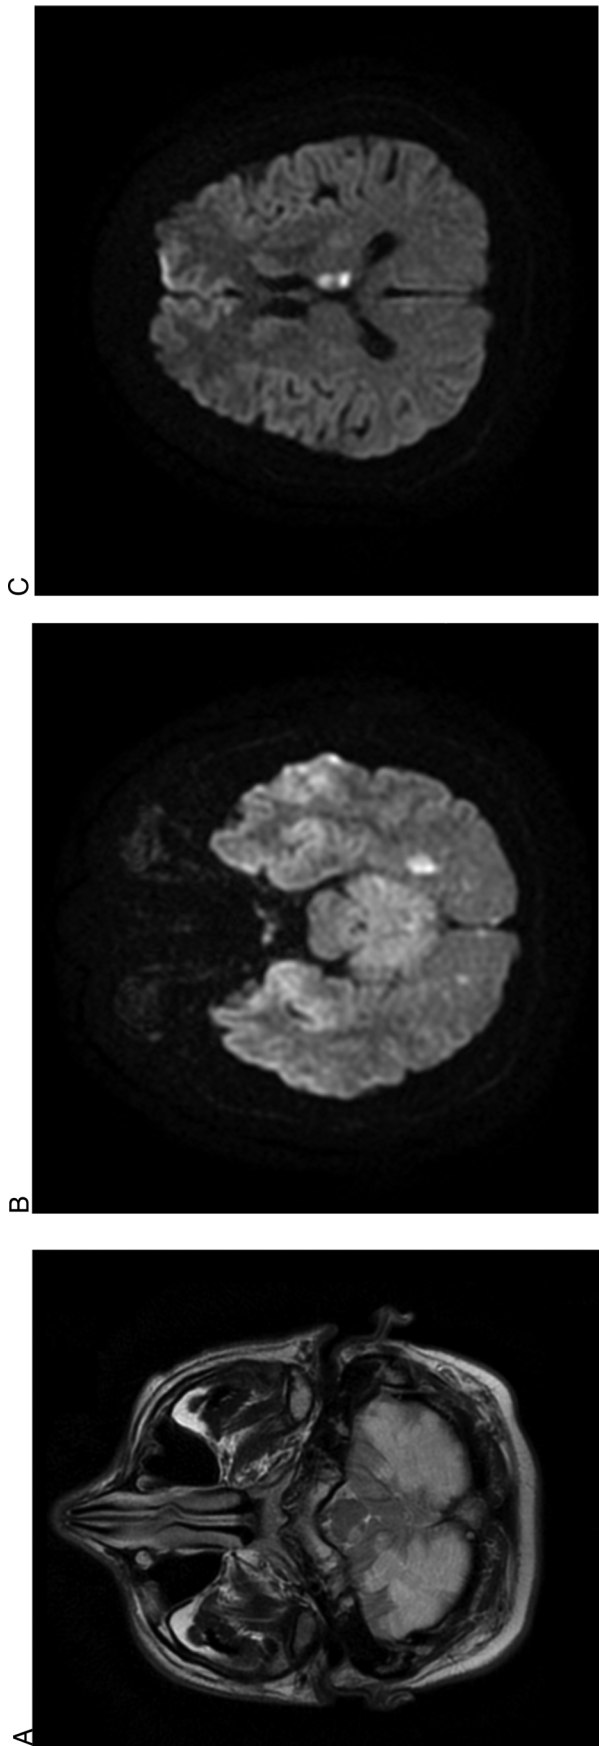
(A–C) Diffuse infarct areas in bilateral cerebellar hemispheres and right mesencephalon (A), left occipital (B), left thalamic area (C) in cranial MRI.
